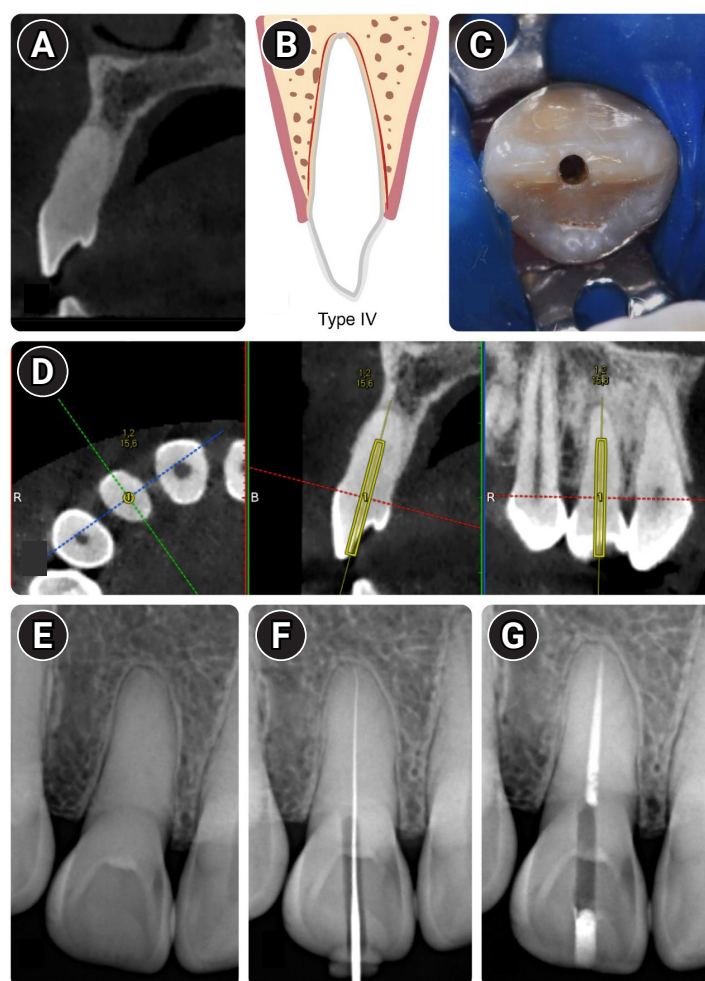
Characteristics of Type IV root canal classification. (A) Tomographic image. (B) Type IV classification scheme. (C) Access to pulp chamber/root canal. (D) Navident (ClaroNav Inc., Toronto, ON, Canada) graphical interface for root canal access planning. (E) Initial radiograph. (F) Initial root canal negotiation with a file to determine the temporary working length. (G) Filled canal.
